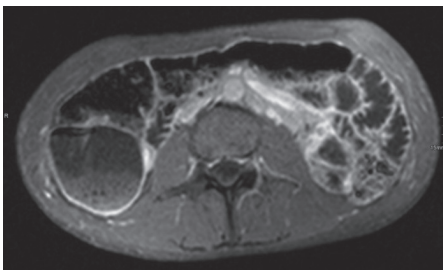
MRI abdomen. Transversal T1-weighted image after contrast with fat saturation shows mild enhancement of the wall of the colon and small intestines.
